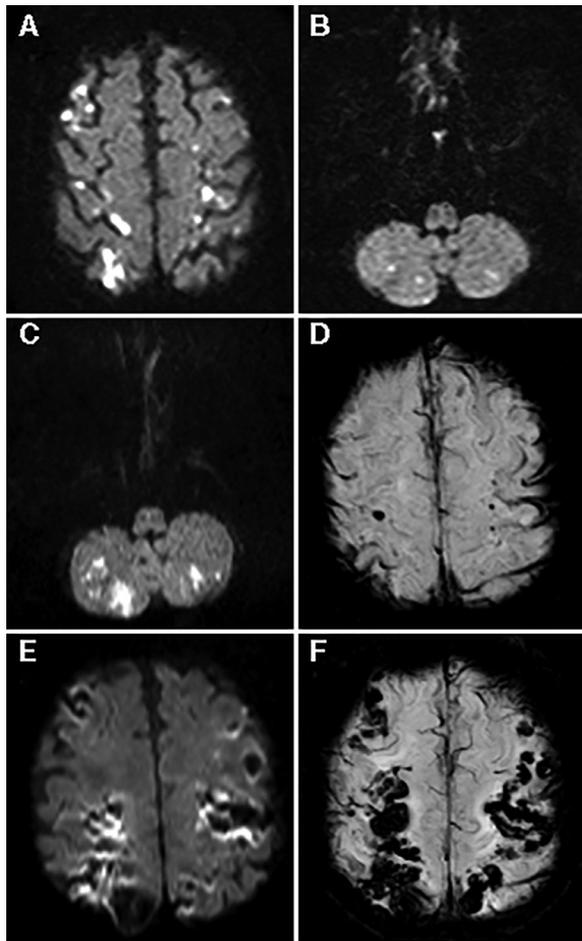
(A, B) Brain magnetic resonance imaging (MRI) on admission. Diffusion-weighted (DW) images showing acute multiple infarction in bilateral cerebral (A) and cerebellar (B) hemispheres. (C, D) Brain MRI on day 3. DW image showing recurrence of cerebellar infarction (C). Susceptibility-weighted (SW) image showing hemorrhagic infarction (D). (E, F) Brain MRI on day 22. DW (E) and SW (F) images showing deterioration of hemorrhagic infarction.
